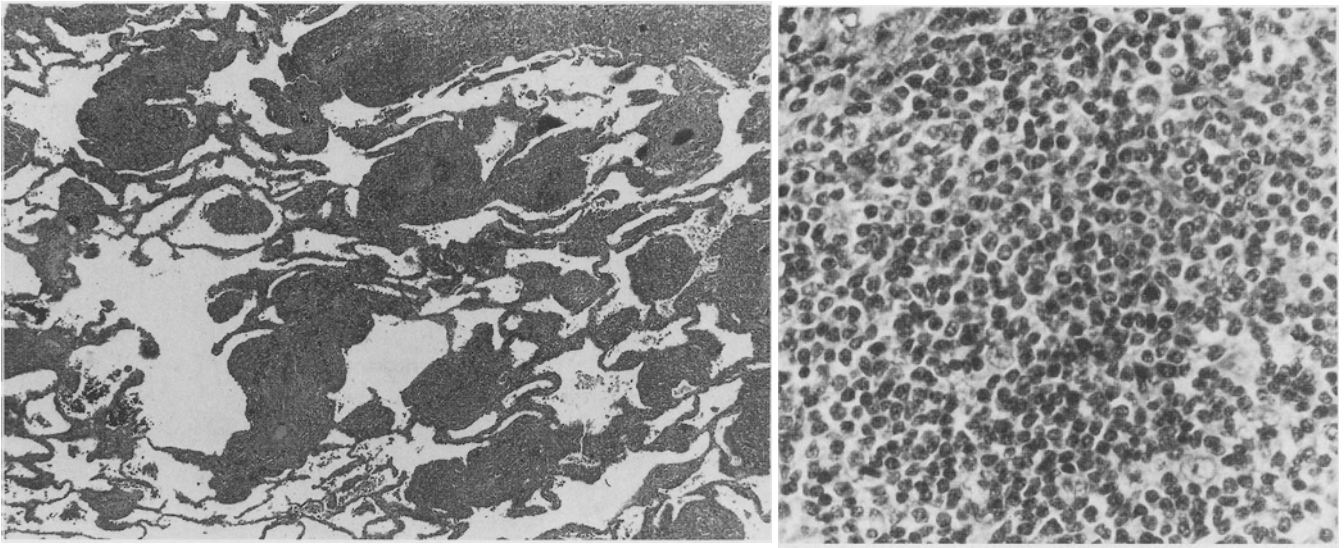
Small lymphocytic lymphoma presenting as diffuse radiographic infiltrates. Biopsy shows pleural and perivascular monomorphous infiltrates of small lymphocytes.
